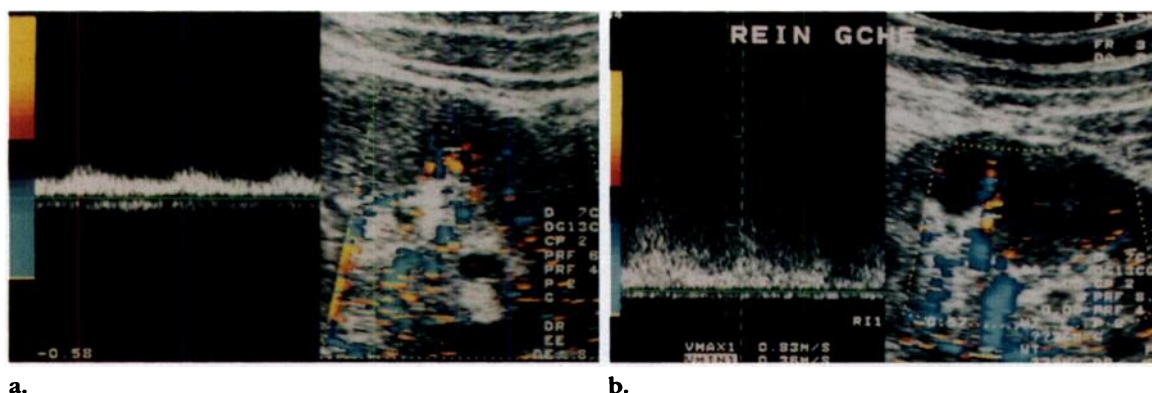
Severe arteriolonephrosclerosis. (a, b) Doppler spectrum (left) and color Doppler sonogram (right) of distal intrarenal arterial branches in the left kidney show inhomogeneous abnormalities of waveforms related to marked slowing of flow in poststenotic or reperused arterial segments (a) and to acceleration of flow with turbulence in narrowed branches (b). The same findings were demonstrated in the right kidney (not shown). (c) Selective angiogram of the left kidney demonstrates typical distal occlusive disease with prominent capsular collateral vessels (black arrowheads) supplying blood to the outer cortex. Note the inhomogeneity of cortical perfusion with obliteration of some distal interlobar arteries (white arrowheads). The same findings were demonstrated in the right kidney (not shown).
